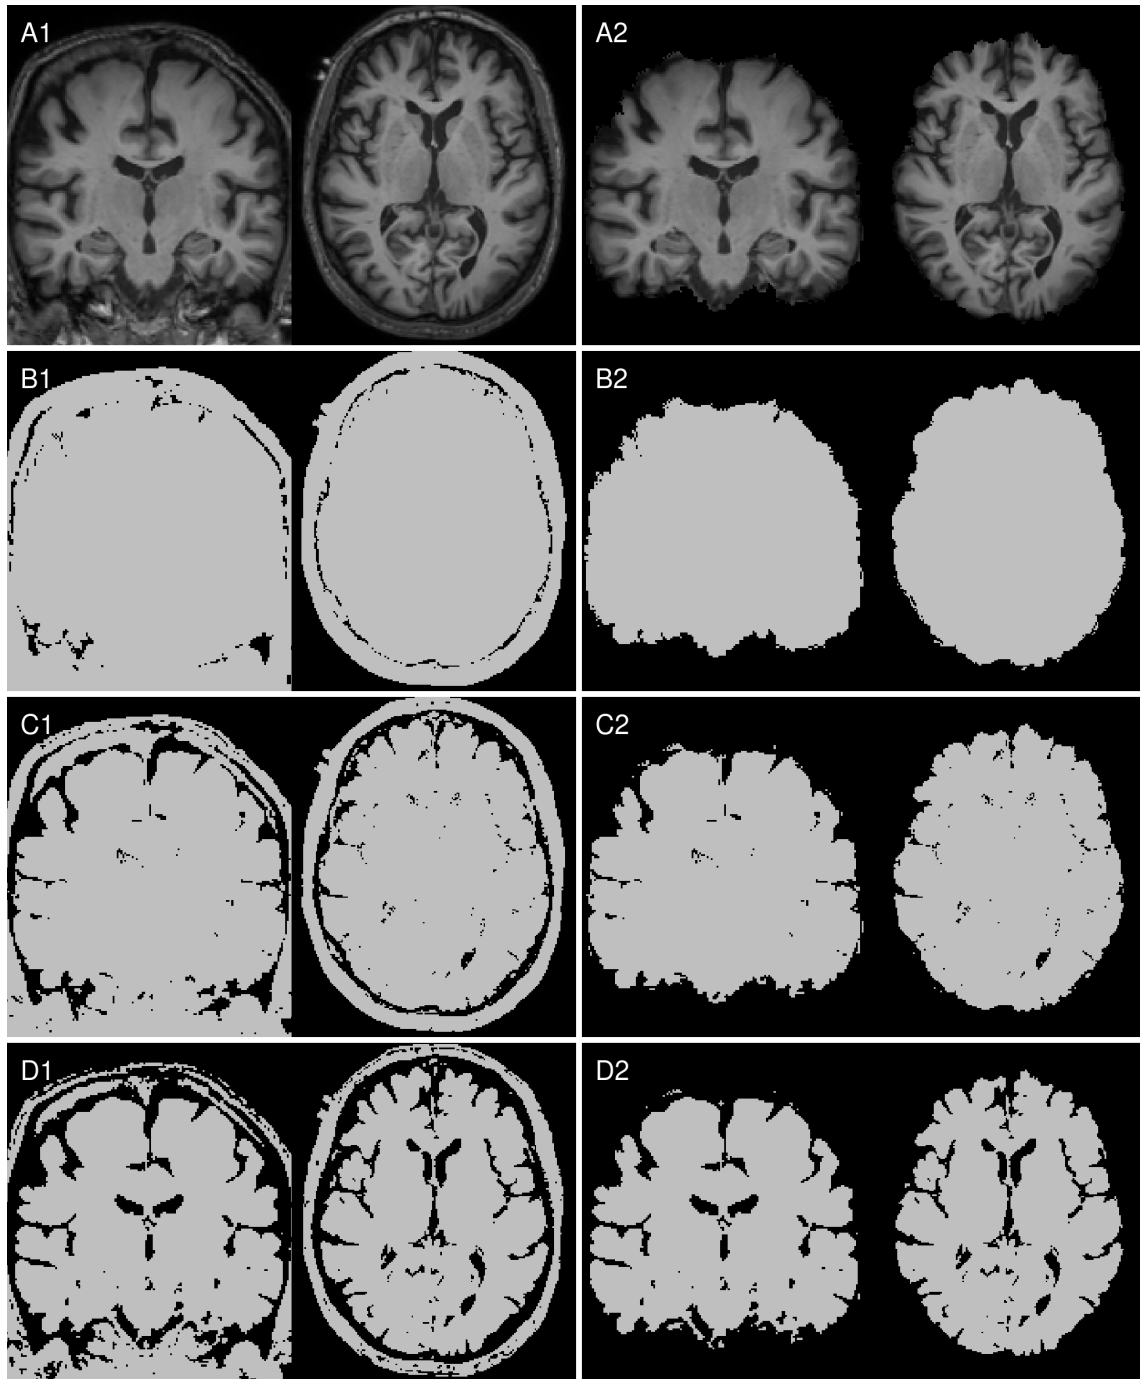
Input image setups: Left column with (A1) aligned T1w MRI, identical binarized T1w images with the manually selected threshold levels (B1) 13.75%, (C1) 27.50% (C1) and (D1) 41.25%, and in the right column the corresponding skull-stripped versions (A2, B2, C2, D2).
